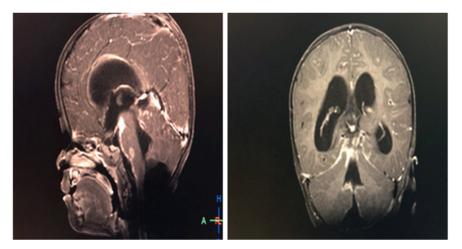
MRI brain showing basal exudates and non obstructive hydrocephalus.
